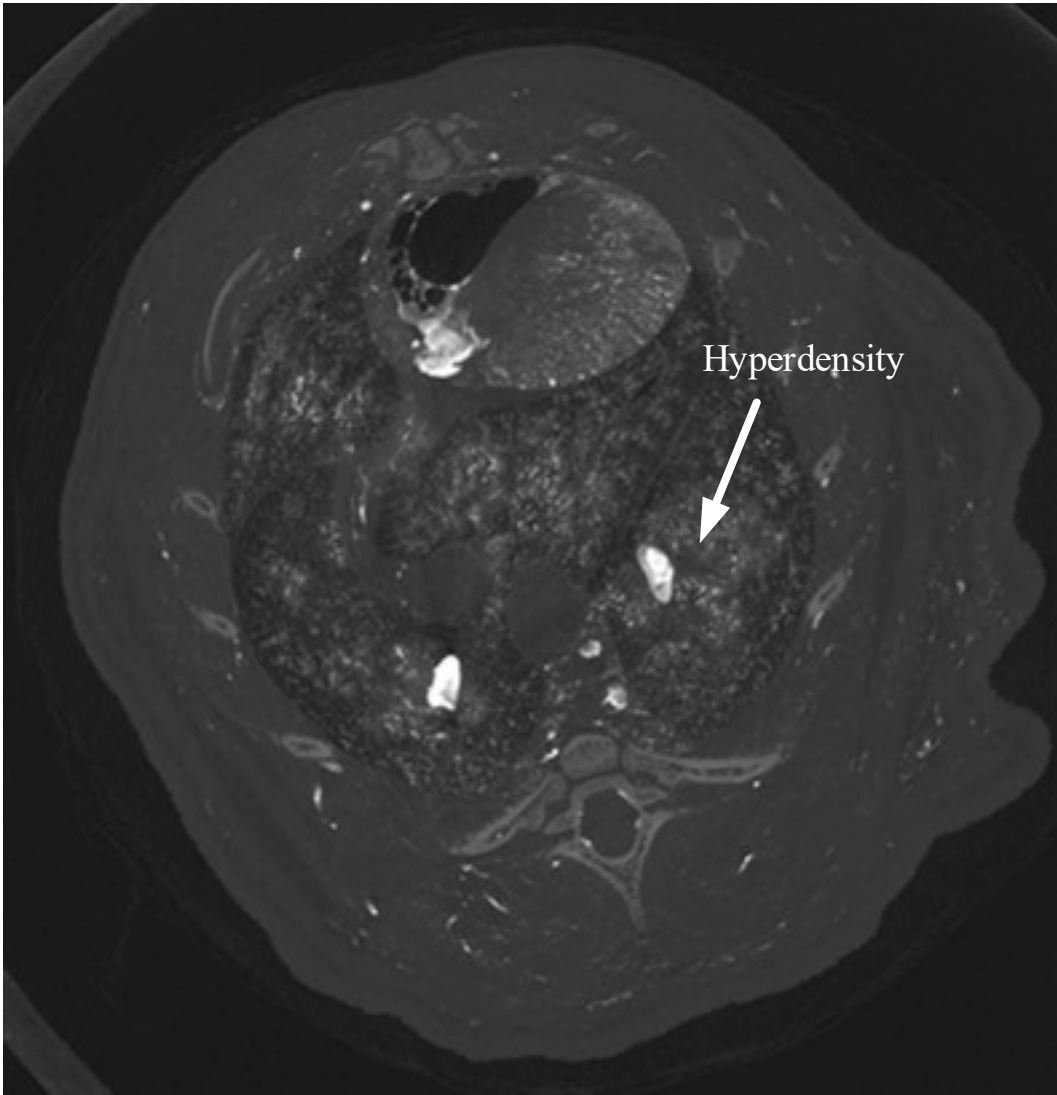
Micro CT images demonstrating regional hyperdensity consistent with parenchymal lung injury.
